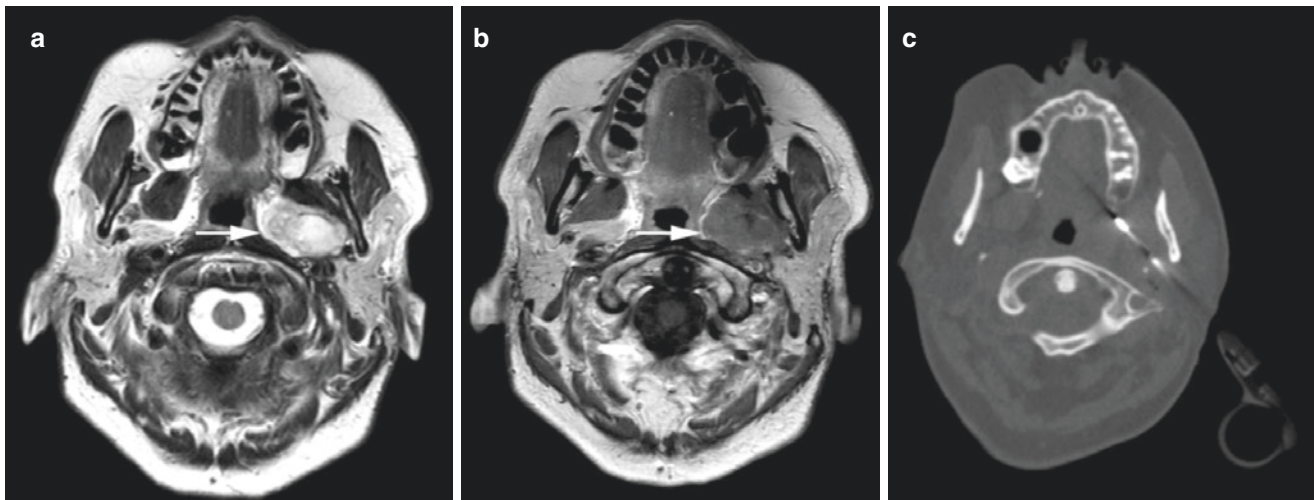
Parotid (deep lobe) acinic cell carcinoma; 69-year-old asymptomatic female found to have 3 cm parapharyngeal mass on head MRI (obtained due to headache). (A) Axial T2-weighted MRI shows well-defined expansive, multicystic, intermediate signal intensity mass
